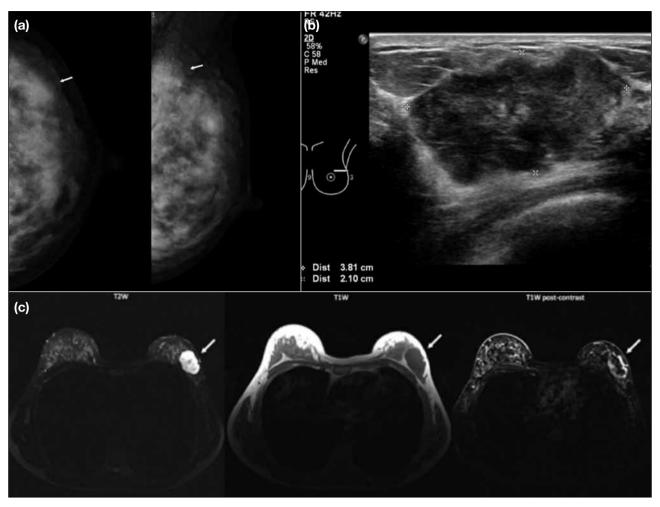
A 39-year-old woman presenting with a history of self-detected breast mass for 3 months. Following diagnosis, neoadjuvant chemotherapy was given, followed by skin and areolar sparing mastectomy with transverse rectus abdominis muscle skin flap reconstruction surgery. (a) An oval equal-density mass (arrow) was seen in the left breast upper outer quadrant on mammogram with craniocaudal (left) and mediolateral-oblique (right) views. (b) Ultrasonogram showed a parallel and hypoechoic mass. (c) On magnetic resonance imaging, the lesion showed high signal intensity on T2-weighted image, low signal intensity on T1-weighted image, and rim enhancement on post-contrast sequence. The lesion extended close to the pectoralis major without involvement.
